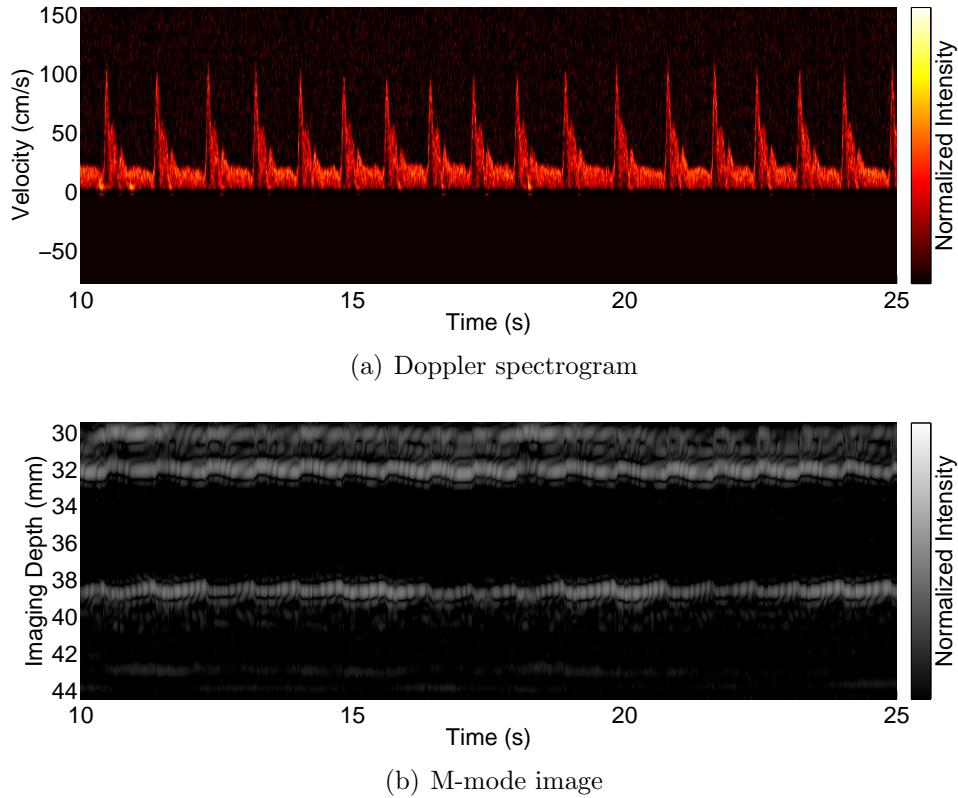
Example of raw ultrasound images obtained from the proof-of-concept clinical study.
